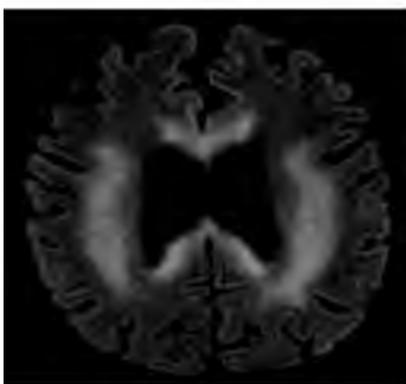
Axial T2 FLAIR image demonstrates confluent periventricular T2 hyperintense signal with extensive involvement of the corpus callosum in this patient with seizures and Marchiafava-Bignami.
